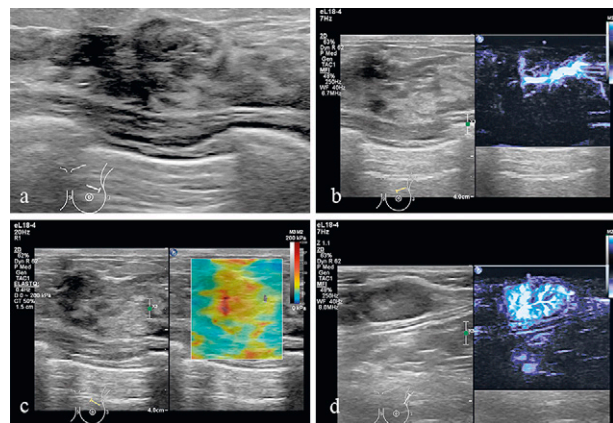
a) A 41-year-old female with a non-mass like lesion locating at the left breast, which proved to be intraductal carcinoma after surgery. B-mode ultrasound showing architectural distortion region with abnormal ductal change at the upper outer quadrant of the left breast; b) A penetrating vessel with multiple uneven branches inside the lesion was displayed by Micro-Flow imaging technique; c) Shear wave elastography showing higher stiffness in the distorted region compared with adjacent tissues; d) Micro-Flow imaging showing complicated and increased vascularity rather than simple hilar flow in a suspicious axillary lymph node.
